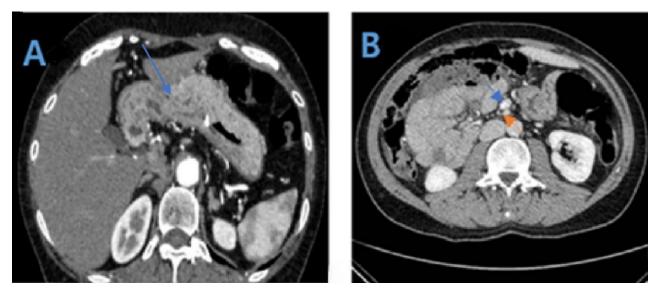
Preoperative computed tomography (CT)-scan. (A) Gastric cancer is located in the posterior wall of the mid-body and has no lymph node metastasis (blue arrow). (B) Small bowel located on the right side of the abdomen. The superior mesenteric vein (orange arrow) is located on the left side of the superior mesenteric artery (blue arrow).
